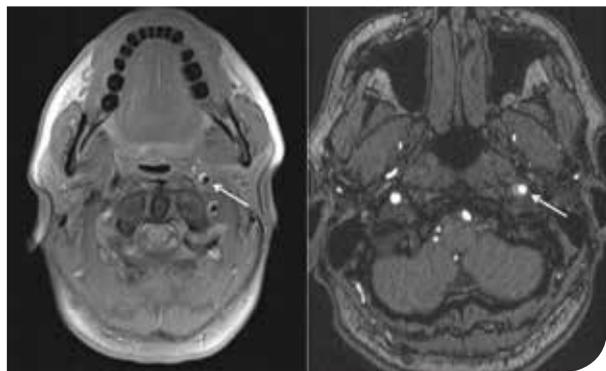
Axial T1 MRI and time-of-flight MRA showing a crescent sign in the left internal carotid artery
